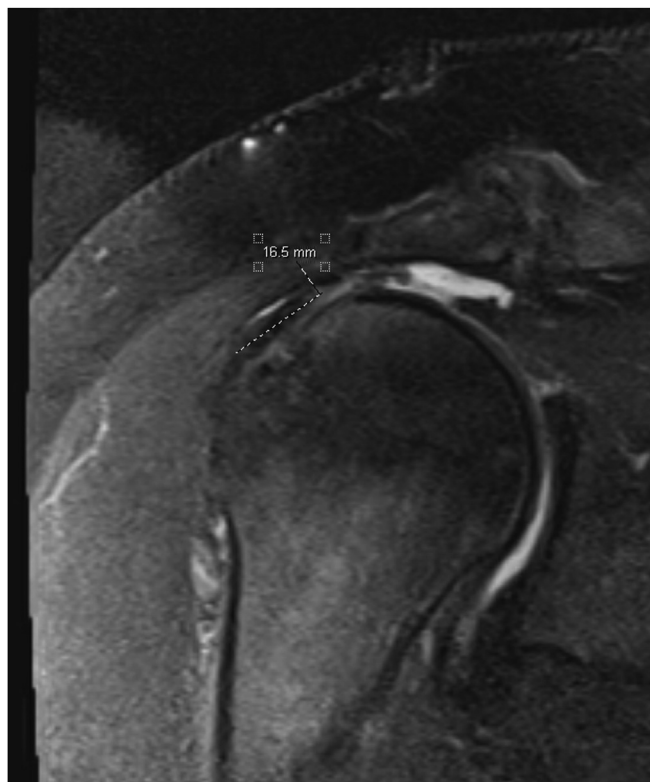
Image demonstrating measurement of tendon length on footprint on coronal T2 right shoulder MRI. MRI, magnetic resonance imaging.
